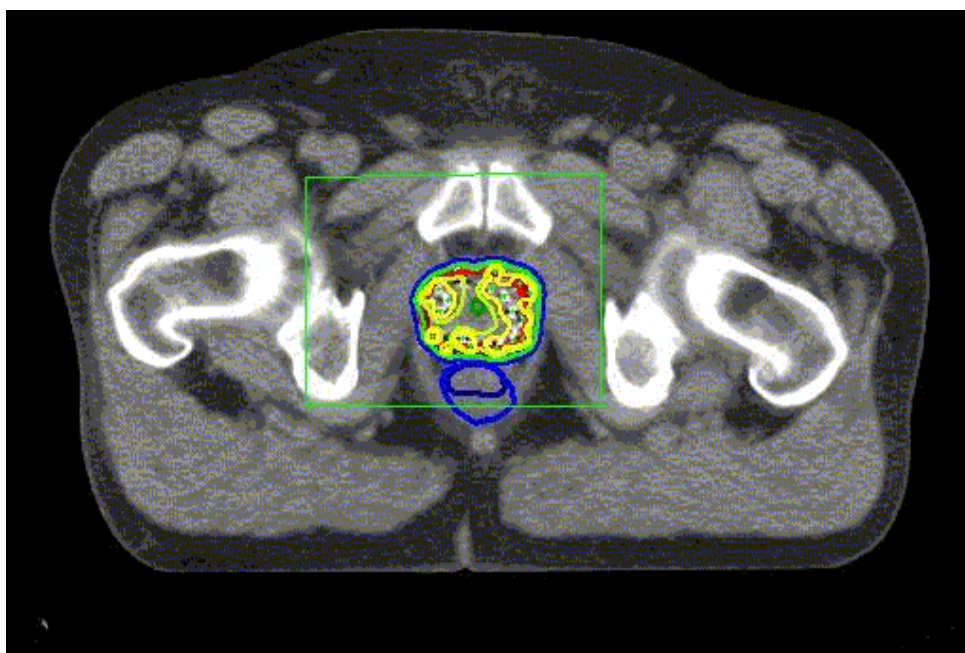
Screen dump of CT scan from post dosimetry using Vari Seed 7.1.
